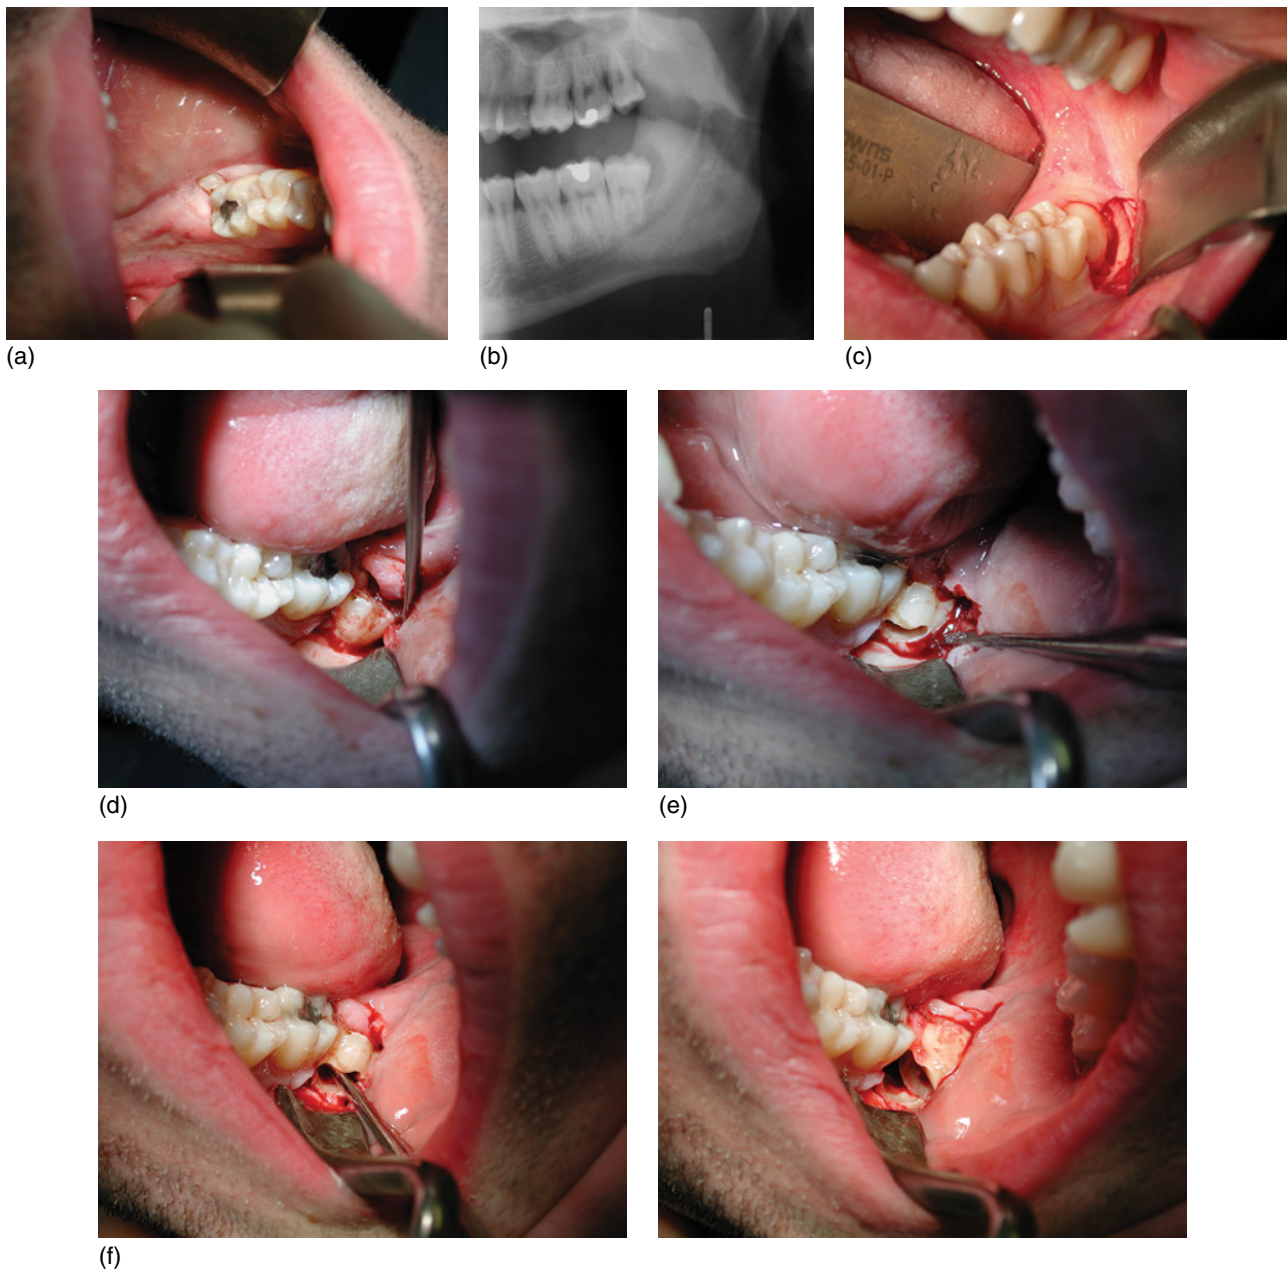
(a) Lower left third molar (LL8). (b) Preoperative orthopantomogram. (c) Minimal access buccal incision for section of third molars. (d) Buccal bone removal fissure bur. (e) Sectioning crown from root. (f) Elevator used for elevating crown. Now LL8 roots can be elevated.
